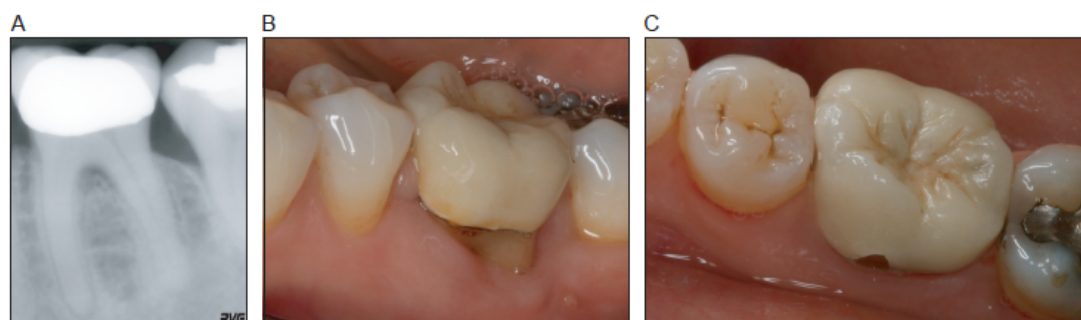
Case 2, 13 months post-op Radiograph (A) and clinical photographs (B,C).
